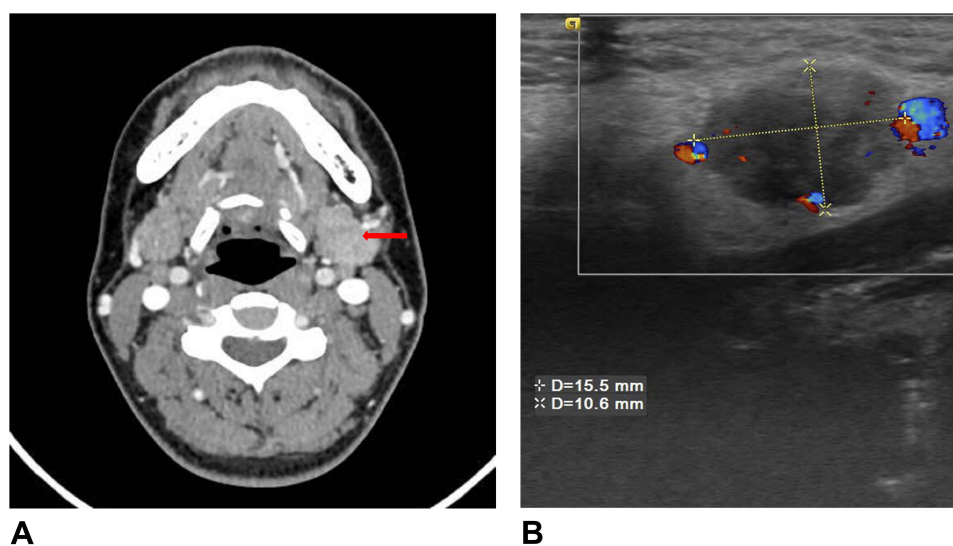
Computed tomography scan showing an enhanced mass located in the left submandibular gland. Red arrows: sebaceous carcinoma mass (A). Ultrasound examination revealed a mixed-component nodule in the left submandibular gland (B).
